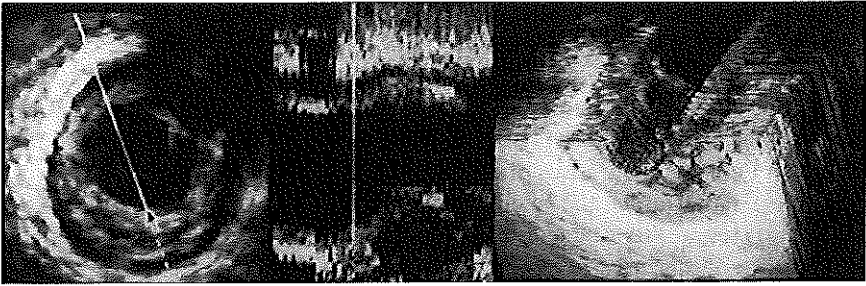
Intracoronary ultrasound cross-sectional image (left panel), taken at the level shown (middle panel), with the equivalent three-dimensional reconstruction (right panel). Note the detailed morphology visible on three-dimensional reconstruction.
